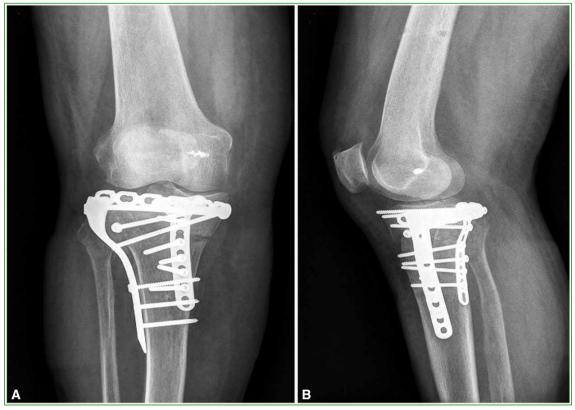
Postoperative frontal (A) and lateral (B) radiograph of the knee.
